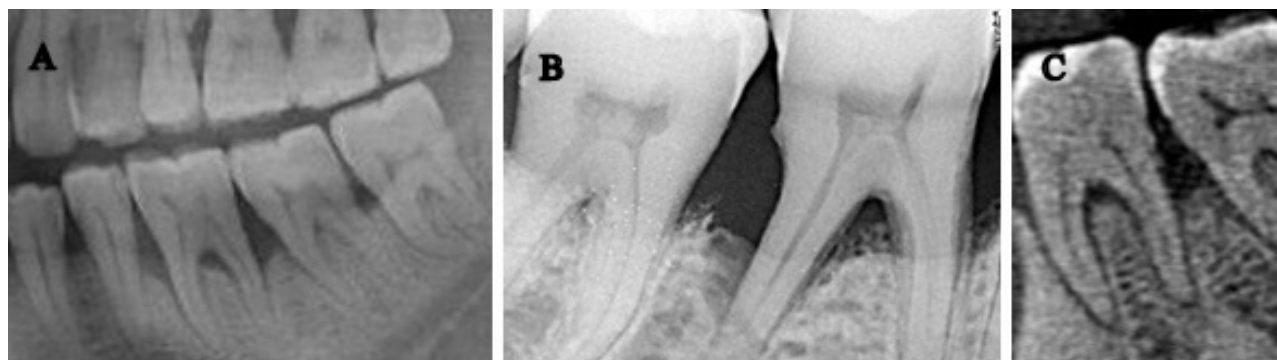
Radiographic techniques of furcation measurement: A) A section of an orthopantomograms (OPG) showing furcation involvement with respect to a mandibular molar; B) A radiovisiograph (RVG) showing furcation involvement with respect to a mandibular molar; C) A cone beam computed tomograph (CBCT) of a mandibular molar with furcation involvement.
